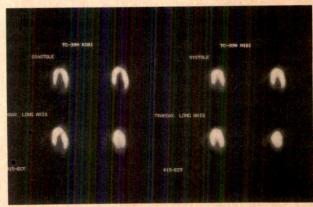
Normal gated single photon emission computed tomography study: consecutive end-diastolic (left) and end-systolic (right) slices in horizontal long-axis orientation. Note normal thickening and homogeneous perfusion. Transax. = transaxial; other abbreviations as in Figure 2.
